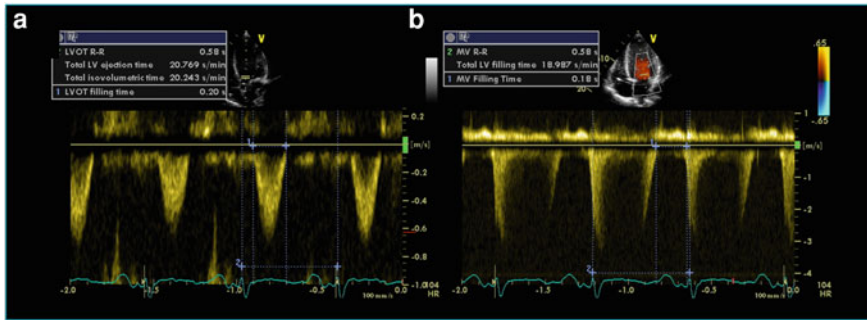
Tei index and total isovolumic time measured using Doppler echocardiography. a LVOT PW Doppler taken from the apical 5-chamber view. b MR (CW Doppler) from the apical 4-chamber view. Tei index: $[440 - 200]/200 = 1.2$. ET: $0.2 \times 014 = 20.8$ s/min, FT: $0.18 \times 104 = 18.9$ s/min. tIVT: $60 - (20.8 + 18.72) = 20.2$ s/min. LVOT; left ventricular out-flow tract; PW; pulse wave, MR; mitral regurgitation, CW; continuous wave, ET; ejection time, FT; filling time, tIVT; total isovolumic time
